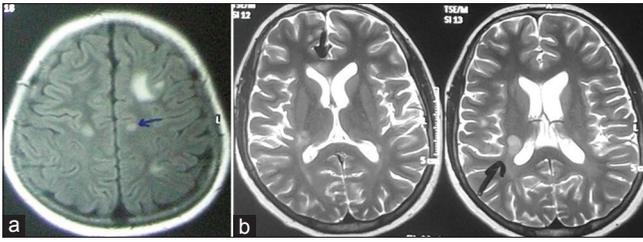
(a and b) Repeat magnetic resonance imaging at third visit showing new foci of demyelination in cerebral white matter (marked by arrows)
